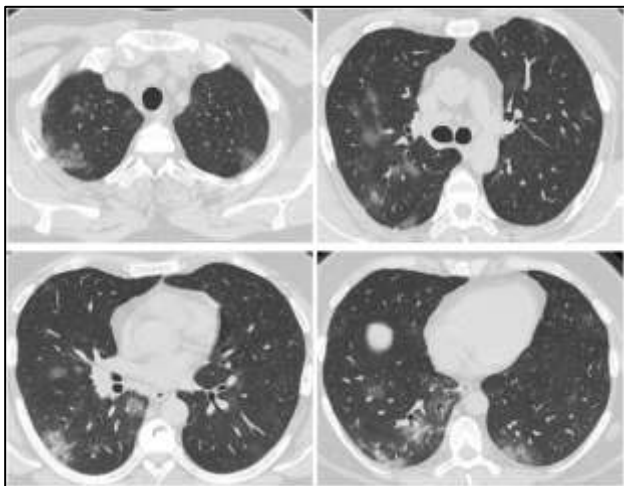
Axial CT sections of the chest in lung window in a 51-year-old male. Multiple peripheral, as well as central patches of GGOs with interlobular septal thickening, were seen. CT severity score – 10/25. This patient had elevated levels of CRP, IL-6, and LDH.
